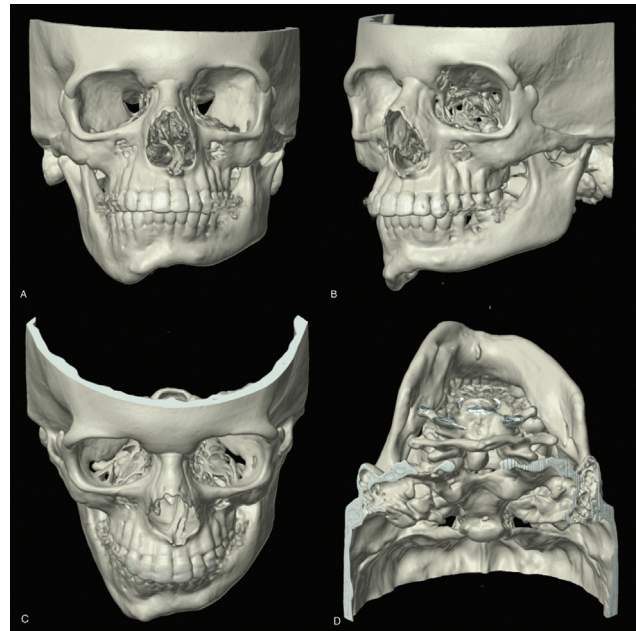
Three-dimensional computed tomography analysis with anteroposterior view (A), oblique view (B), superior view (C), and inferior view (D) showing left mandibular hypoplasia and borderline dysmorphic right mandible contributing to facial asymmetry.
